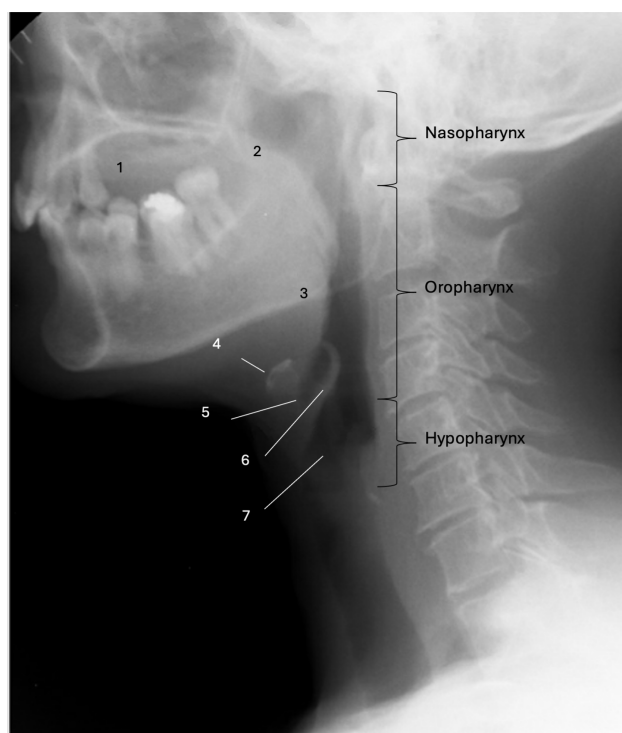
Radiographic anatomical landmarks on lateral view. 1 – oral cavity; 2 – soft palate; 3 – base of the tongue; 4 – hyoid bone; 5 – vallecula; 6 – epiglottis; 7 – laryngeal vestibule.
